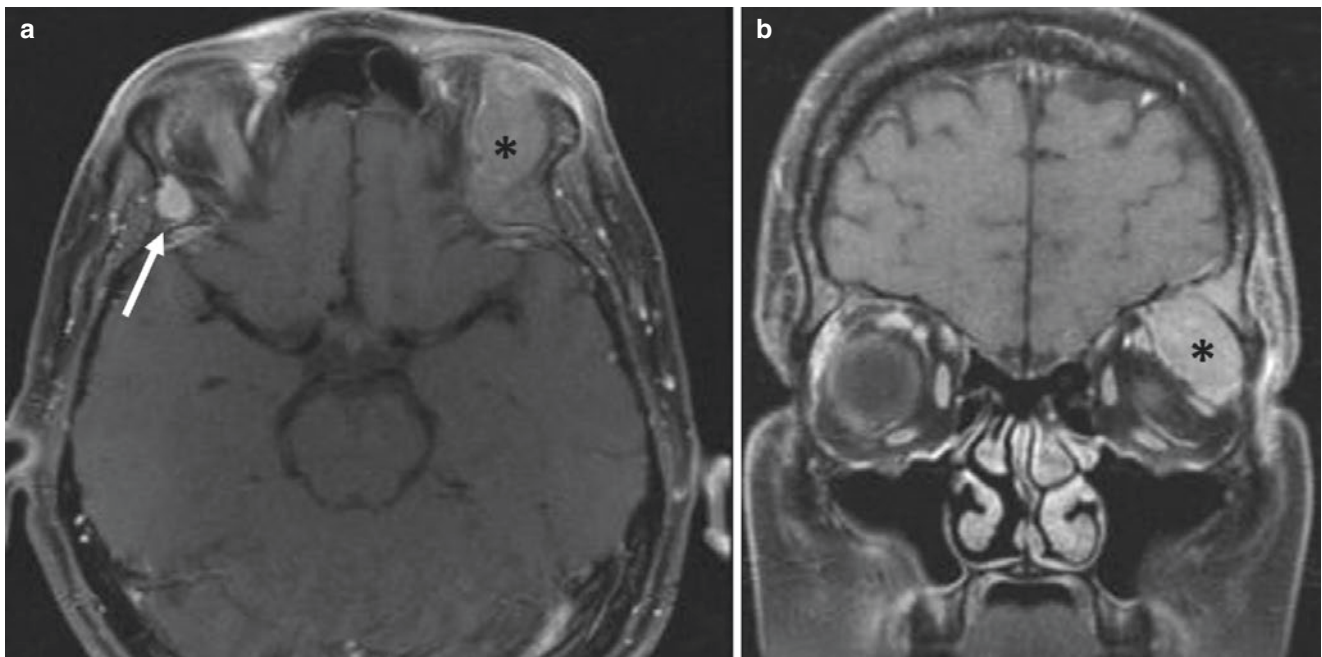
Magnetic resonance imaging: (a) axial, (b) coronal: T1w+C images show an enhancing extraconal mass in the left superomedial orbit (*) with involvement of the adjacent bone, as well as a clinically
